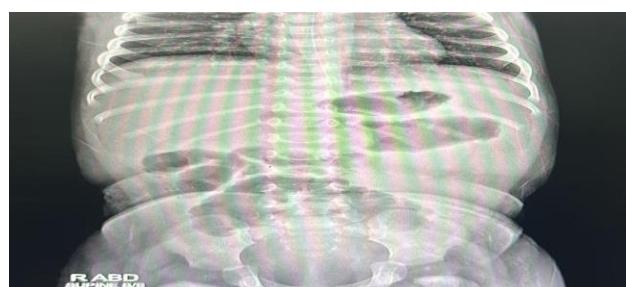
Radiograph images showing gas filled small bowel loops.
